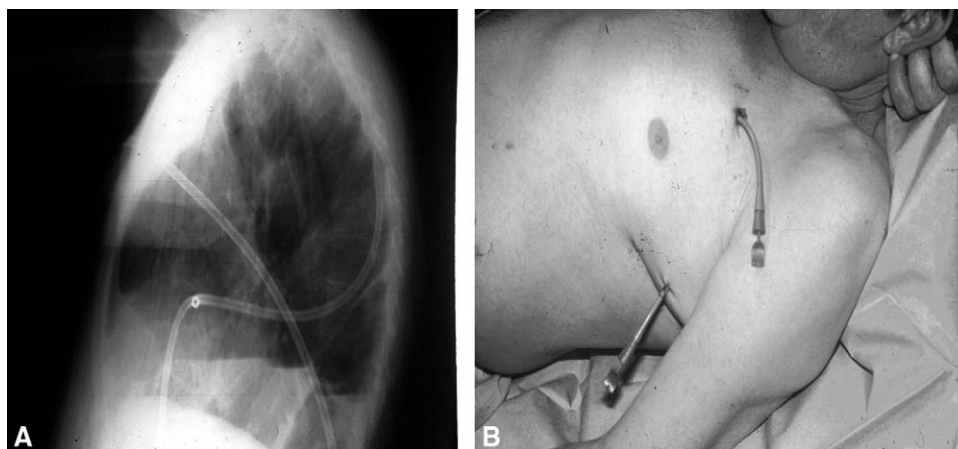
Axillar and anterior chest tube placement for antibiotic irrigation after left-sided PPE. A, Chest x-ray film. B, Position of chest tubes.
